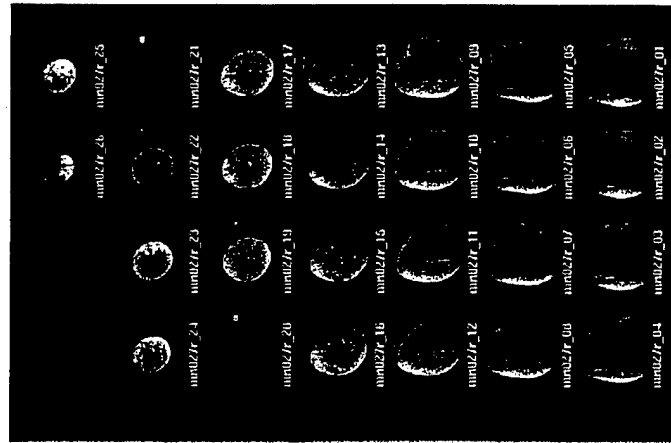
MR images of the right breast of a patient. The two-view mammogram of the same breast is shown in Fig. 2.
